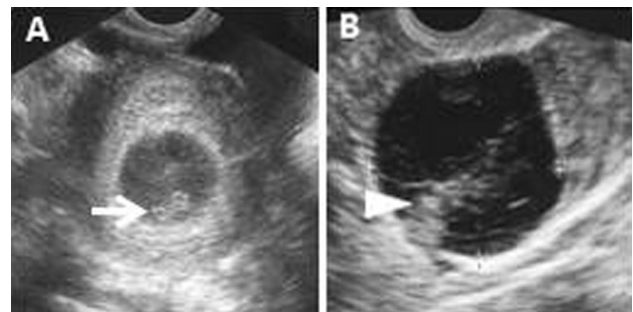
Transvaginal ultrasonography at the presentation. A) Intrauterine fetus with 11.5-mm crown-rump length (arrow). B) Left ovarian cystic tumor 47 mm in diameter containing internal solid part (arrowhead).
